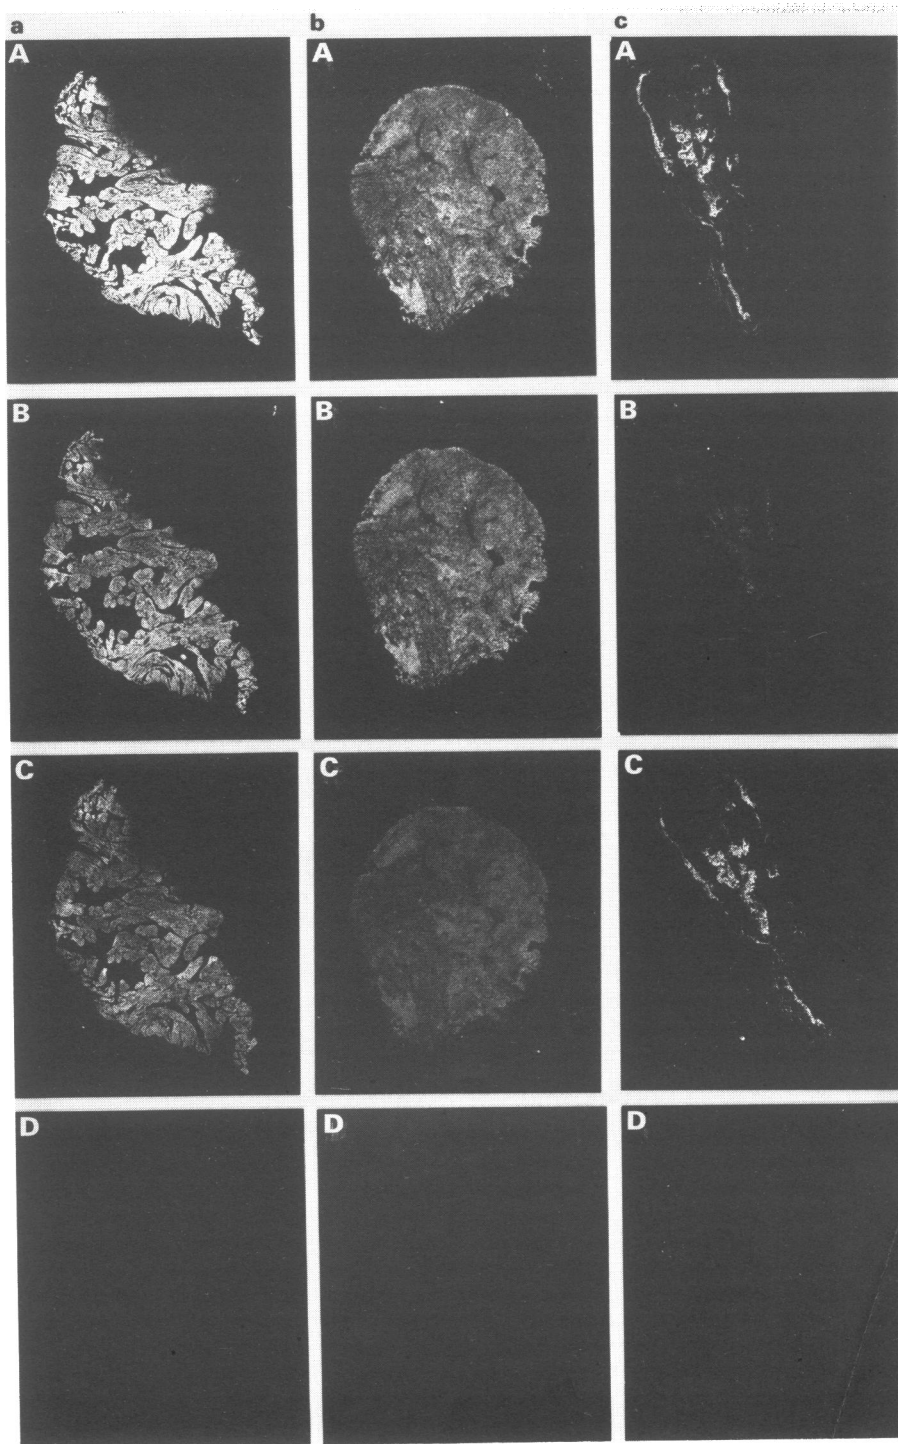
Photographs of X-ray film images showing the distribution of $(-)-[^{125}\text{I}]$ -cyanopindolol (CYP) binding sites in serial sections of (a) right atrial appendage, (b) left ventricular papillary muscle and (c) pericardium. Sections were incubated with 50 pM $(-)-[^{125}\text{I}]$ -CYP in the absence (A) or presence of (B) 70 nM ICI 118,551, to occlude β_2 -adrenoceptors, or (C) 100 nM CGP 20712A, to occlude β_1 -adrenoceptors, or (D) 1 μM $(-)$ -propranolol, to occlude both β_1 - and β_2 -adrenoceptors. Note the high and even distribution of β_1 - and β_2 -adrenoceptor sites in the right atrial appendage and left ventricular papillary muscle. The pericardium showed a minor population of β_1 - and predominance of β_2 -adrenoceptors.
